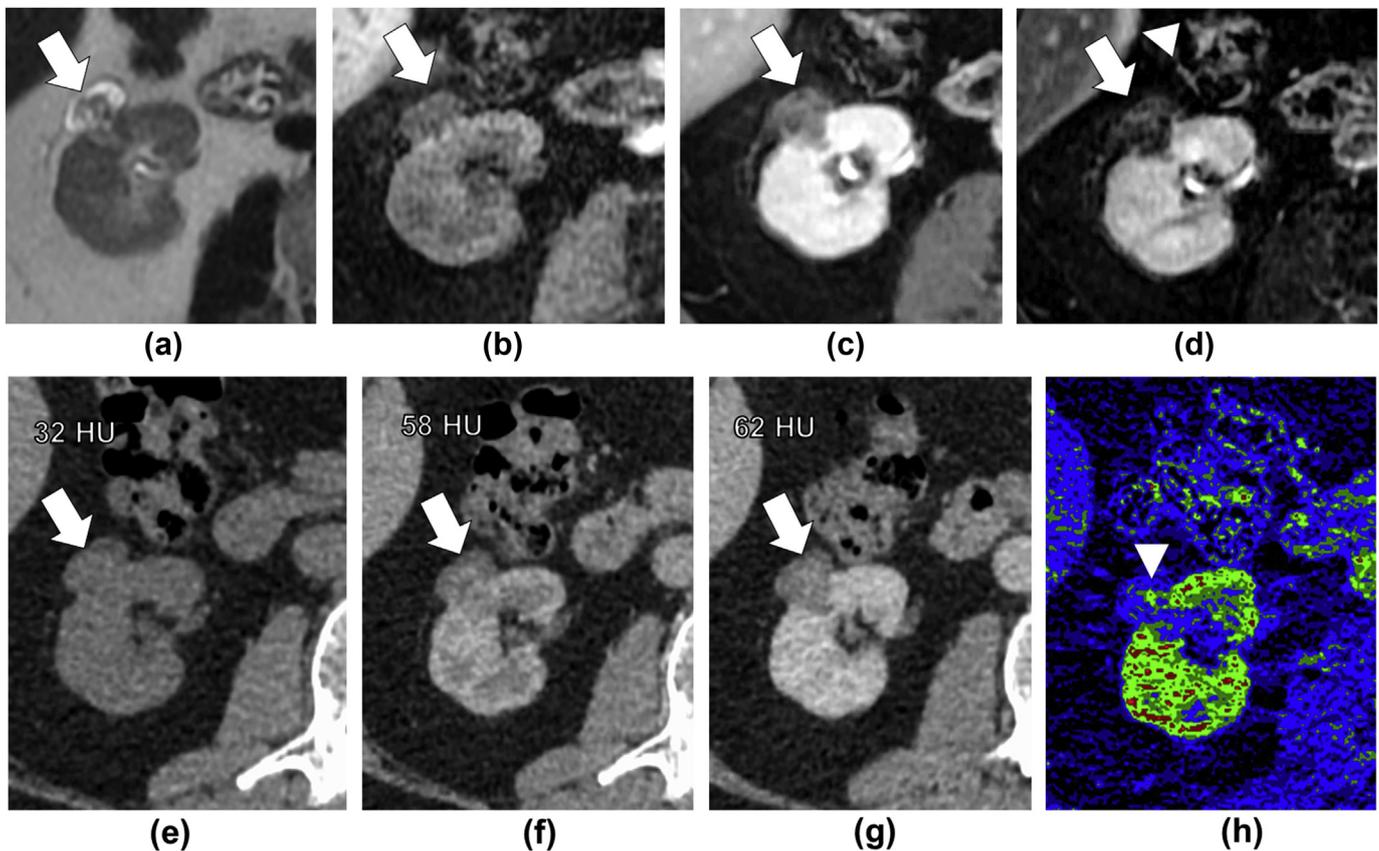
A 47-year-old woman with incidentally detected complex cystic right renal mass on ultrasound performed for left upper quadrant pain. MRI was performed to further characterise. (a) Axial T2-weighted single-shot fast spin echo (ssFSE) image shows a complex cystic mass in the right kidney (white arrow). Axial T1-weighted fat-suppressed images before (b) and after (c) gadolinium injection during the nephrographic phase of enhancement are degraded by motion artefacts. (d) The subtraction image was also degraded by motion (edge [ringing]) artefacts at the liver edge (arrowhead) and enhancement was deemed indeterminate. Follow-up CT was suggested. DECT was performed showing definite internal enhancement of the thick septa comparing pre-contrast axial (e), corticomedullary (f), and nephrographic (g) phase images (attenuation change >20 HU). (h) Colour iodine overlay image shows definite enhancement of septal components (arrowhead) to a better extent than both conventional CT images and MRI. A Bosniak Type III cyst was diagnosed confidently with CT.
